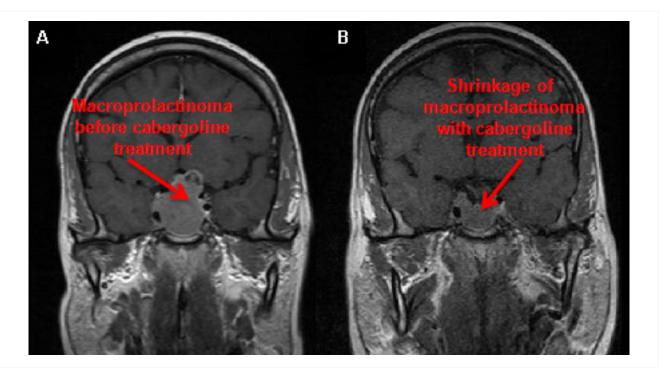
Gadolinium-enhanced magnetic resonance imaging (coronal view) showing a 40 mm pituitary macroprolactinoma in a 41-year-old man before (A) and after (B) 2-month treatment with cabergoline
